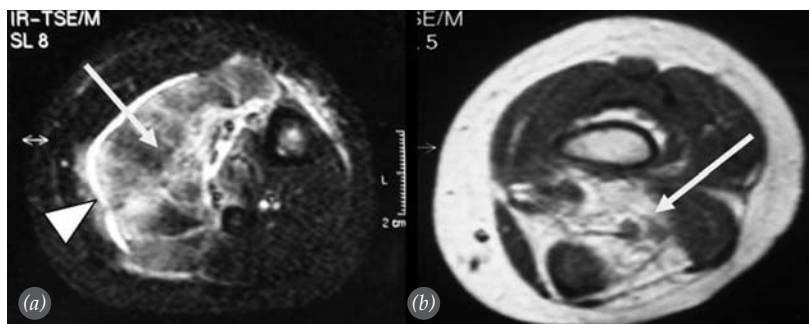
Magnetic resonance imaging revealed enlargement of gastrocnemius and hyperintense signal of muscle (arrow) and deep fascia (arrowhead) in axial T2 STIR sequences (a), while axial post gadolinium T1-weighted images showed enhancement in biceps femoris muscle (arrow) (b).
